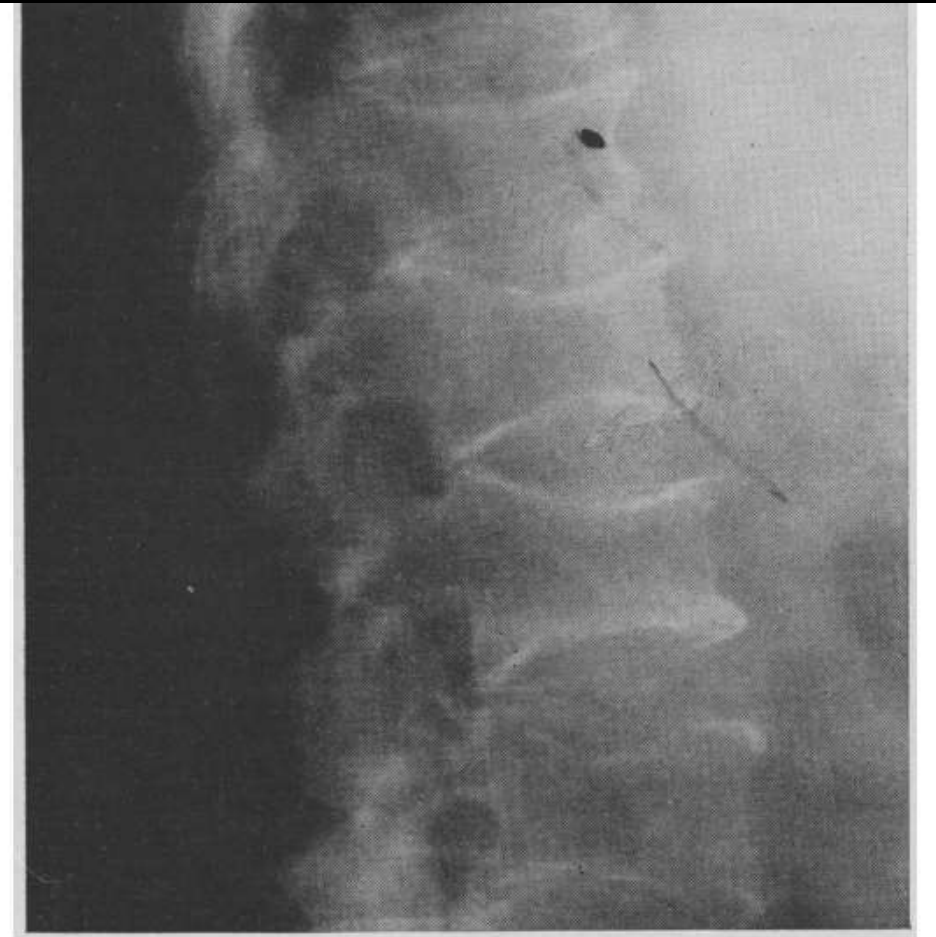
Roentgenogram showing lateral view of the patient reported on in case 1. Partial collapse of several vertebrae and marked generalized osteoporosis are seen.
